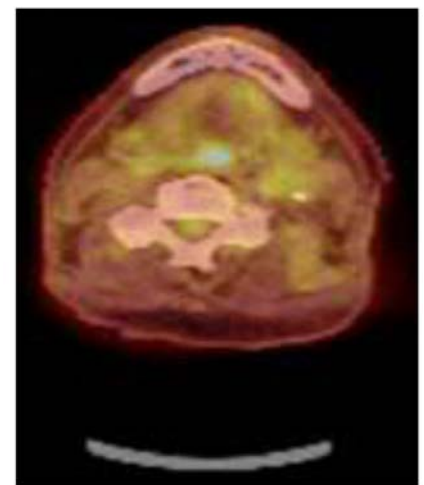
Positron emission tomography/computed tomography. August 2014. Post definitive intensity modulated radiation therapy and chemotherapy, shows patients significant response to treatment.
